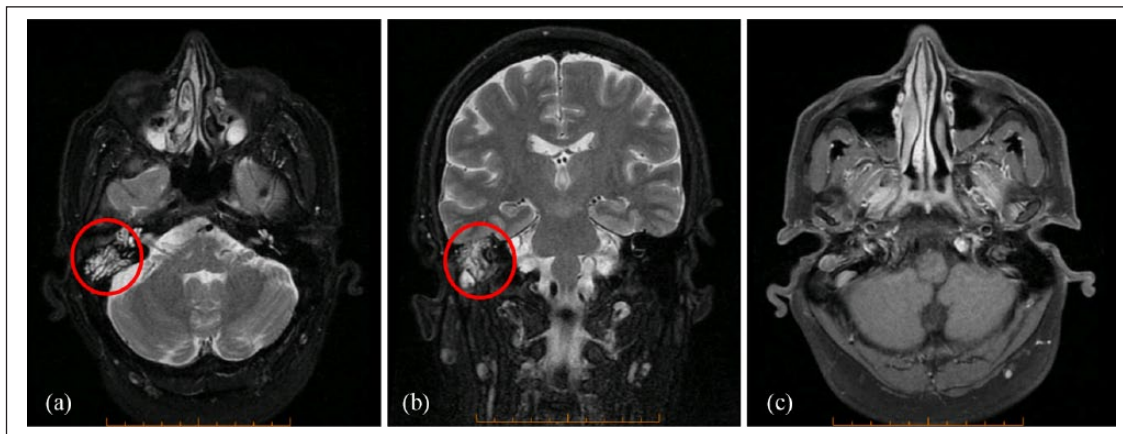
(a and b) MRI T2-weighted images demonstrating hyperintensity of the right mastoid and middle ear cavities due to fluid occupancy (red circle). (c) MRI T1-weighted images post-gadolinium administration demonstrating diffuse inflammation of the nasal lining, nasopharynx and eustachian tubes bilaterally.
